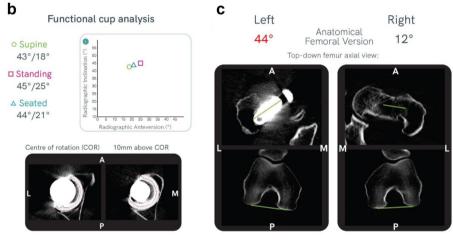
Measurements made on CT imaging: (a) Cup and stem positioning and femoral head size were measured by registering 3D computer models of the implants within the CT image volume. (b) Cup anteversion and inclination were measured in the supine position and transferred to the standing and seated positions. (c) Stem version and anatomical femoral version were measured as the angle between the neck axis and the posterior condyles on the operative and contralateral sides, respectively.
